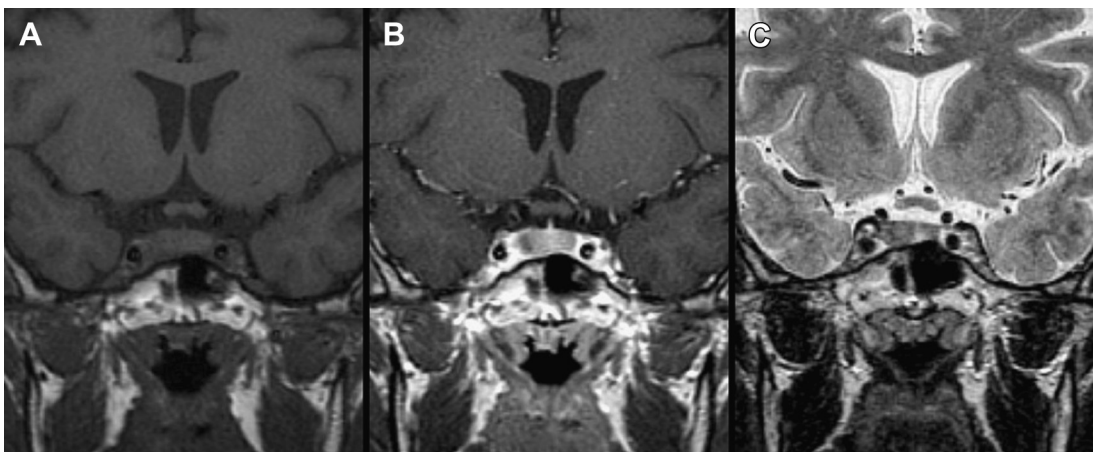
Microadenoma. Subtle intrinsic low T2 signal in the right lobe of the pituitary (A), seen to better advantage on gadolinium-enhanced T1-weighted image as hypoenhancing relative to the surrounding gland (B). This growth hormone-secreting microadenoma appears relatively T2 hypointense compared with normal adenohypophyseal tissue (C).
